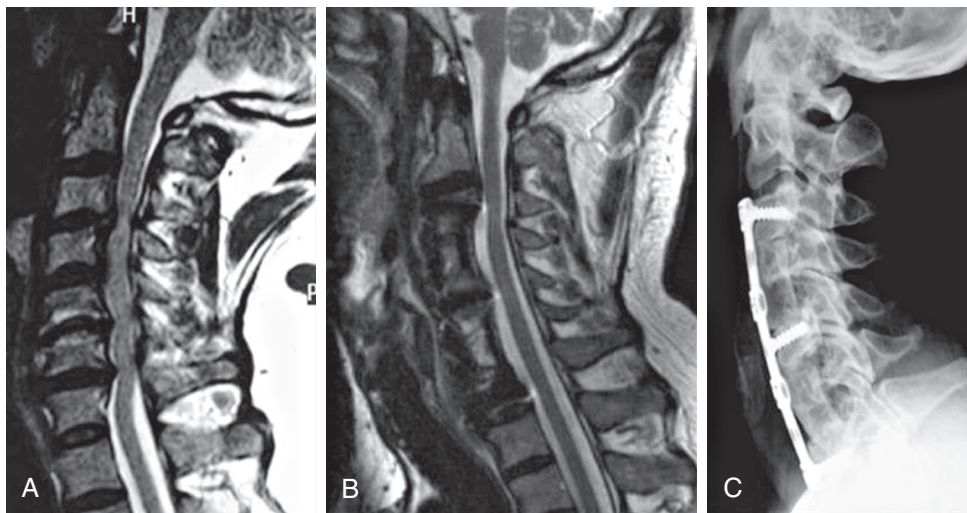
A, Preoperative T₂-weighted sagittal cervical spine magnetic resonance imaging (MRI) showing the multiple ventral compressions. B, Postoperative T₂-weighted sagittal cervical spine MRI showing decompression of the spinal cord. C, Postoperative lateral cervical spine plain radiograph showing the position of the grafts and screws.
